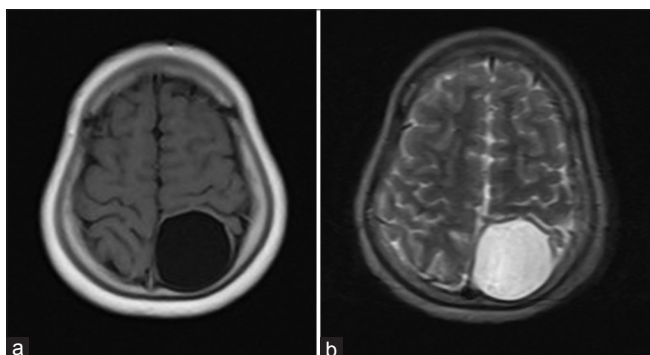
(a and b) Magnetic resonance imaging of the brain in a 13-year-old female with headache. Axial T1- and T2-weighted sequences demonstrate a simple cystic mass in the left occipital lobe
